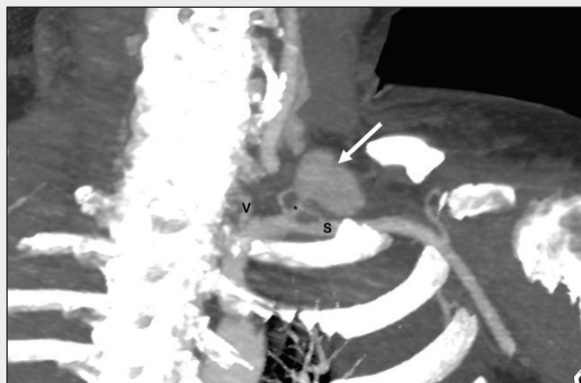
CT image (multiplanar reconstruction) showing the pseudoaneurysm (white arrow) originating from the bifurcation of the left thyrocervical trunk (*). V, vertebral artery; S, subclavian artery.
